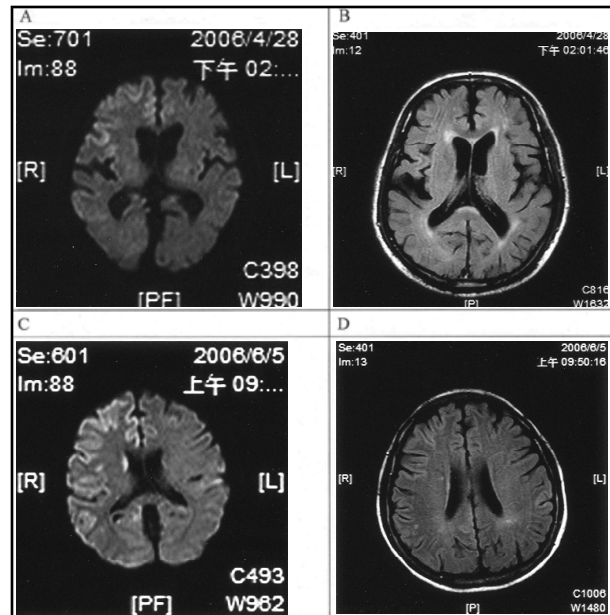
diffusion weight image of brain MRI on case 1 (A) and case 2 (C) revealed abnormal high signal intensity lesions on right cerebral cortex, otherwise the caudate nucleus of case 2 was noted high signal intensity also. The MRI findings of proton density weighted images on case 1 (B) and case 2 (D) were no abnormalities.
